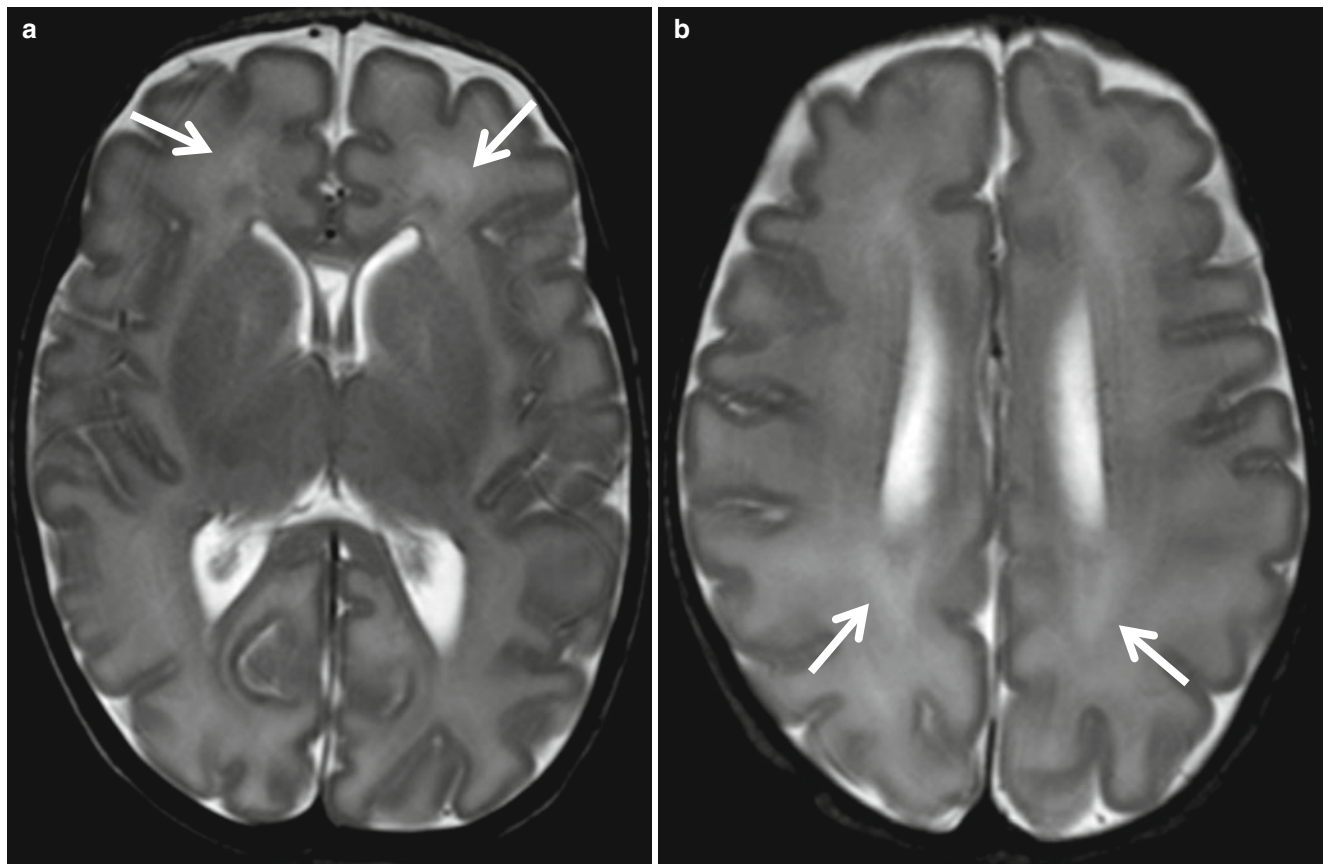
Normal periventricular white matter in preterm baby at corrected gestational age of 35 weeks. (a) On T2-weighted image, developing white matter is seen as high signal intensity areas (*arrows*)
